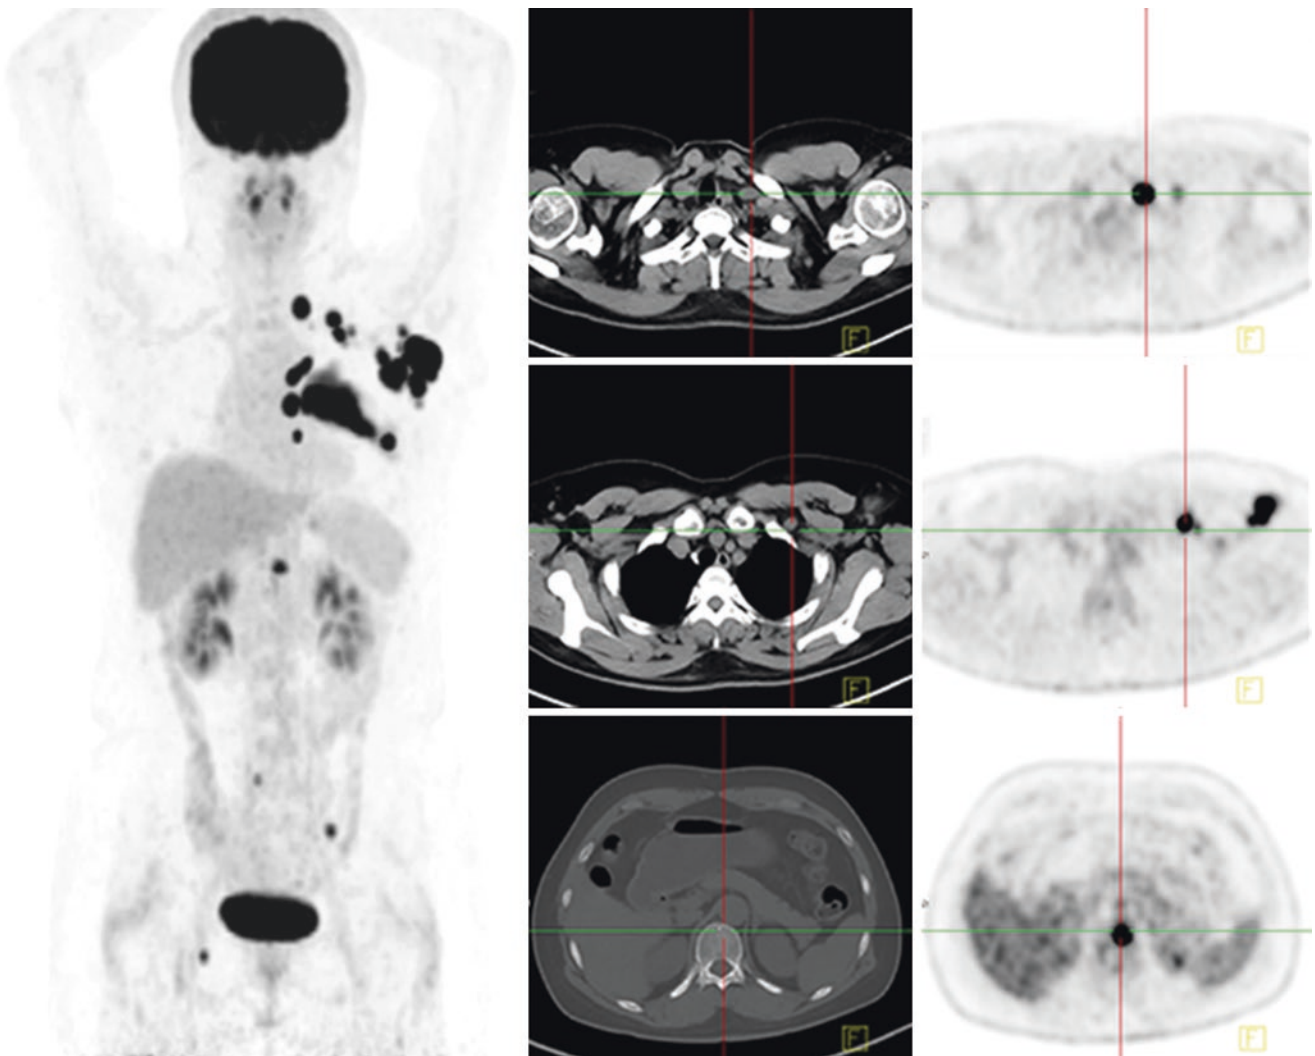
PET/CT—soft-tissue density nodule shadow and mass shadow in the upper quadrant of the left breast and the rear of the nipple, metabolism increased, and malignant lesions were more considered
